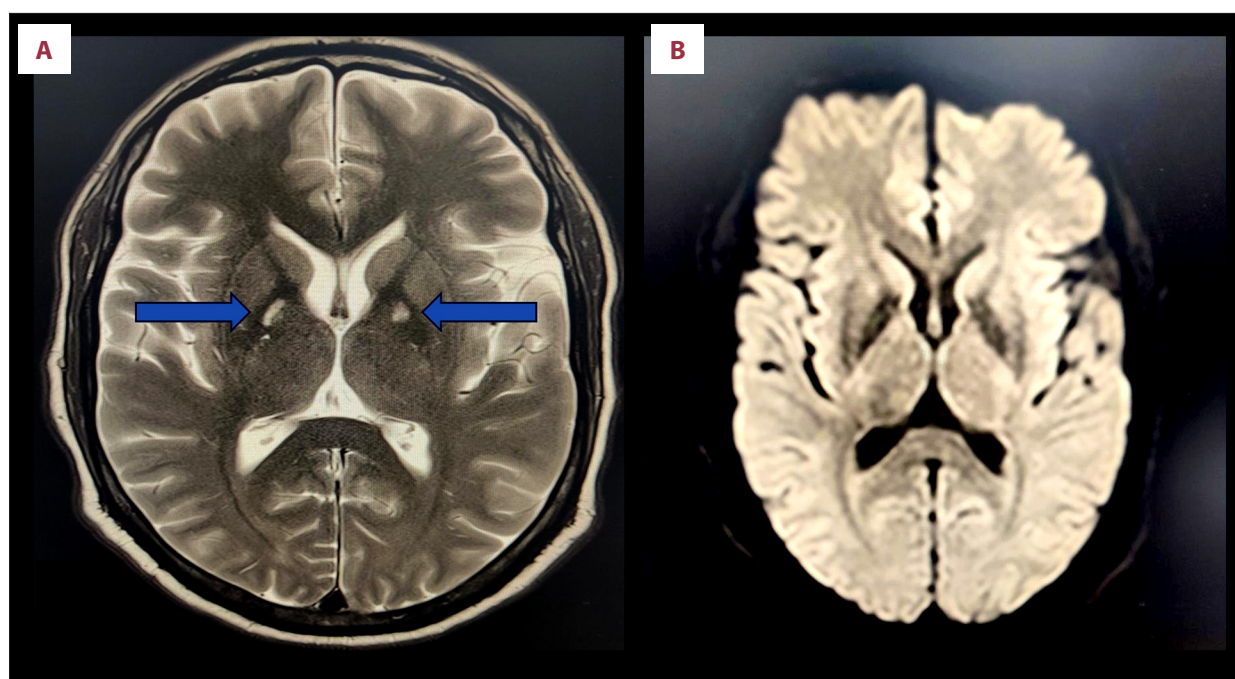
Axial magnetic resonance imaging of the brain demonstrating T2 hyperintensity in the bilateral globus pallidus (indicated by blue arrows) (A), with no corresponding diffusion restriction on the diffusion-weighted image (B).
